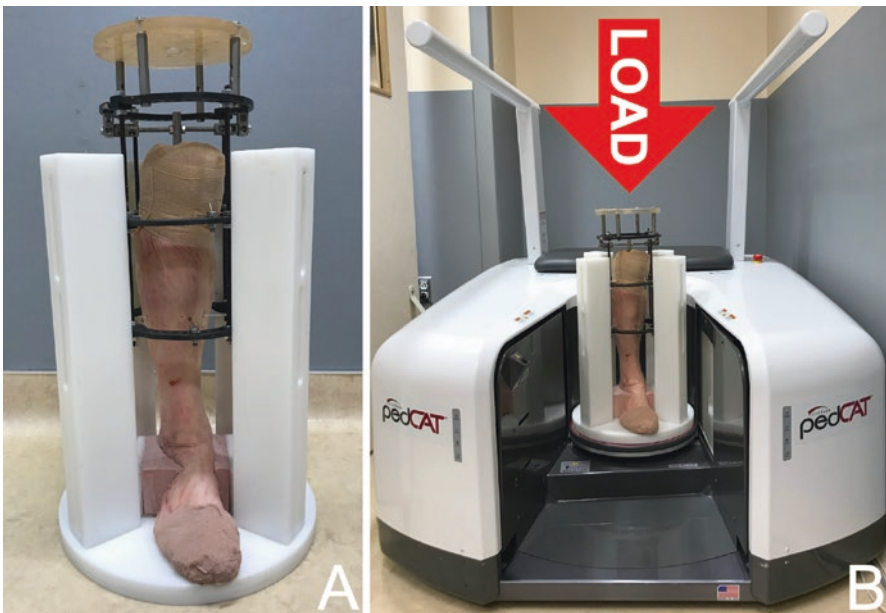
Experimental setting. (a) The foot was fixed in an Ilizarov frame, which fit into a radiolucent frame that held the foot in a plantigrade position. The hindfoot was fixed with two Kirschner-wires (K-wires) and a two-part resin (Bondo®, 3 M). (b) The frame was put into a weight-bearing computed tomography (CT) scanner for data collection. Load was applied to the plate mounted on top of the Ilizarov frame [1]
